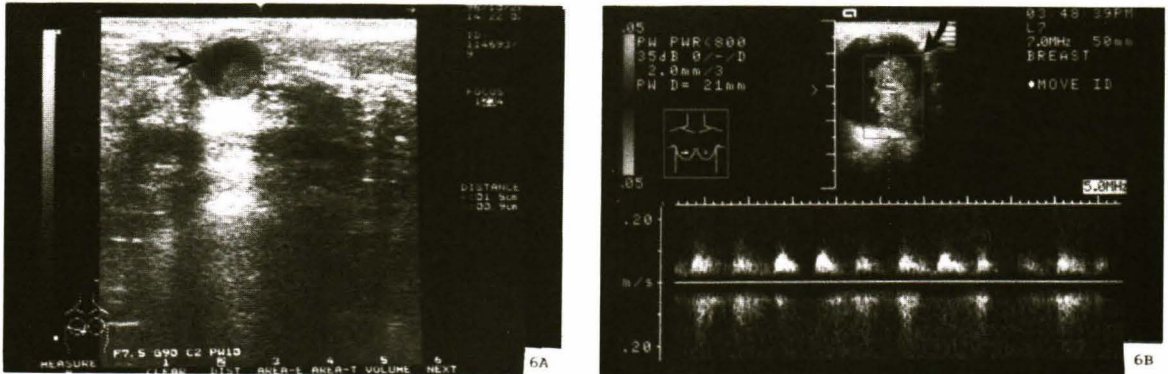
Ultrasonography of two cases showing cystic lesion with intramural nodule, both at right subareolar area (arrow).
